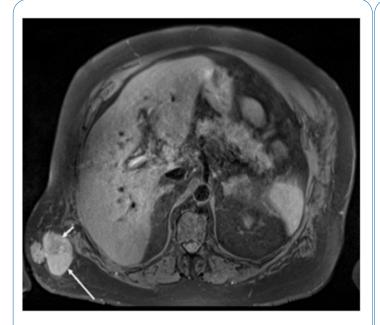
T2-weighted fat saturated MRI reveals the same mushroom shaped mass with hyperintense signal (long arrow) and a hypointense island (short arrow) which corresponds to fat content.
